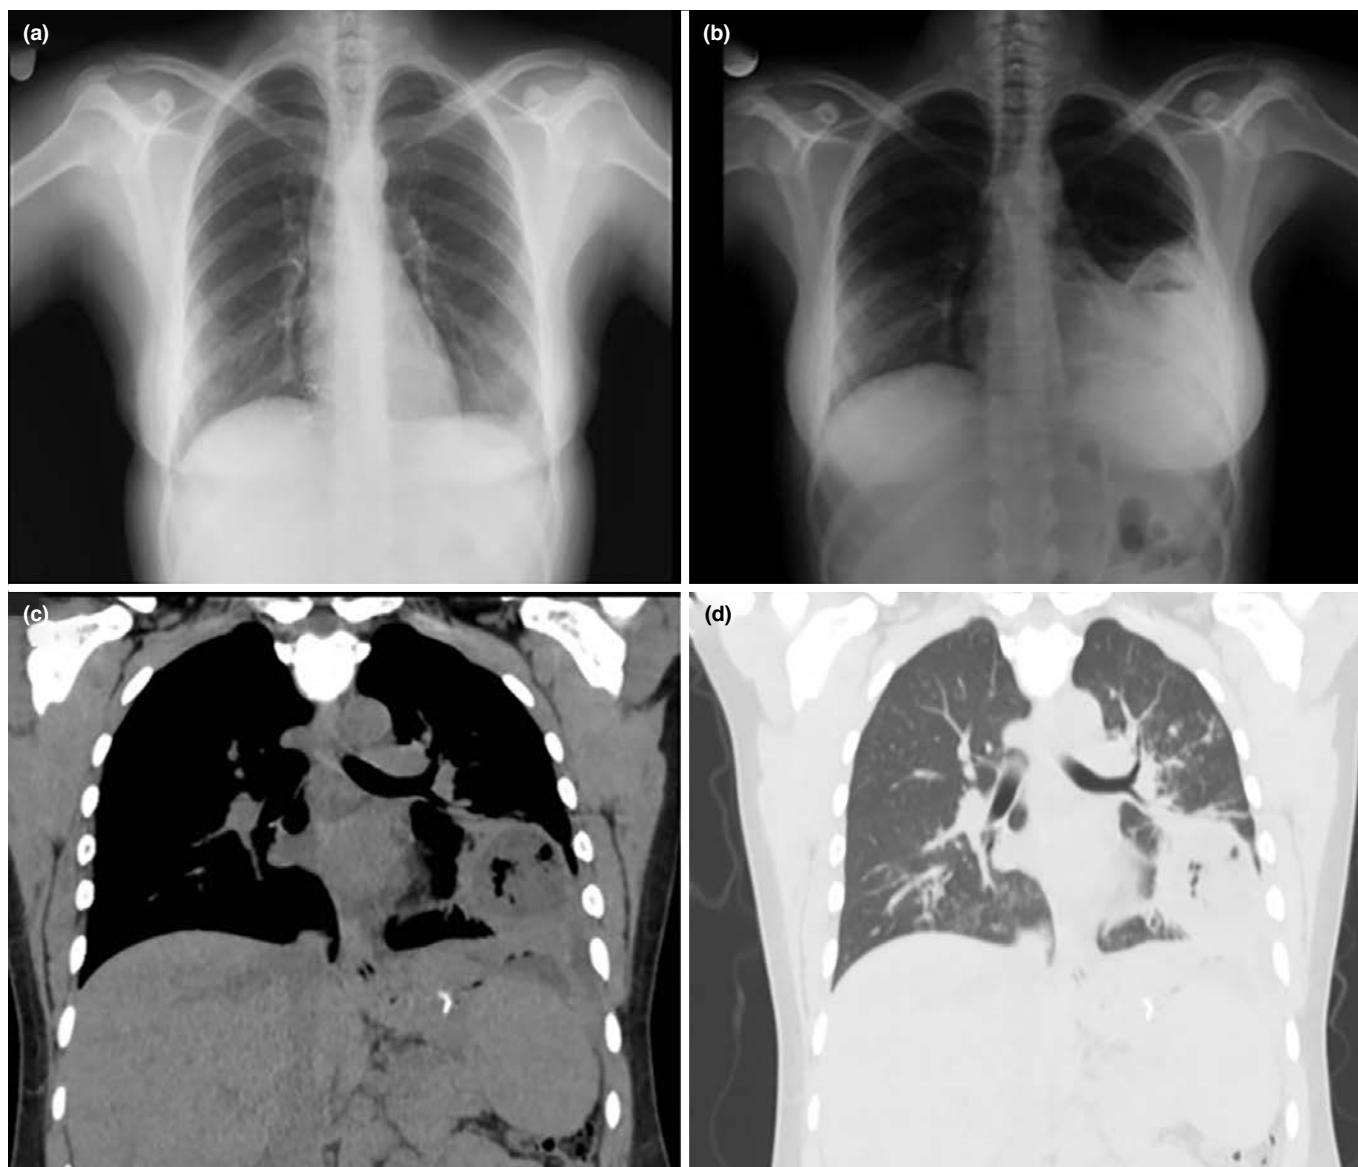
(a) A chest X-ray taken two months ago, which was completely normal before the breast prosthesis operation. (b) A chest X-ray demonstrating an air-fluid level-like density in the left lower zone. (c-d) A thoracic computed tomography (CT) revealing a 5 cm diameter cavitory mass lesion with thick walls and air-fluid densities in the left inferior lingular segment, along with associated consolidated areas
